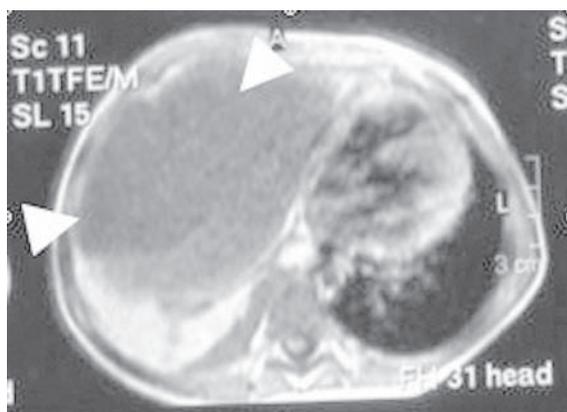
MRI of tumor with cystic and solid parts which occupying entire right lung.
